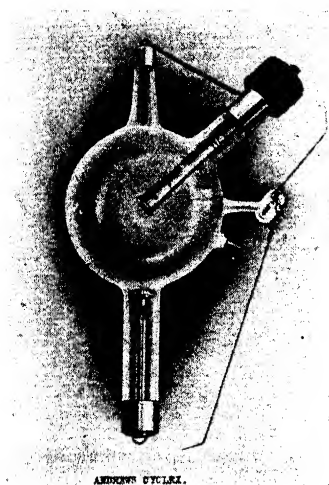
AN EARLY X-RAY BULB
